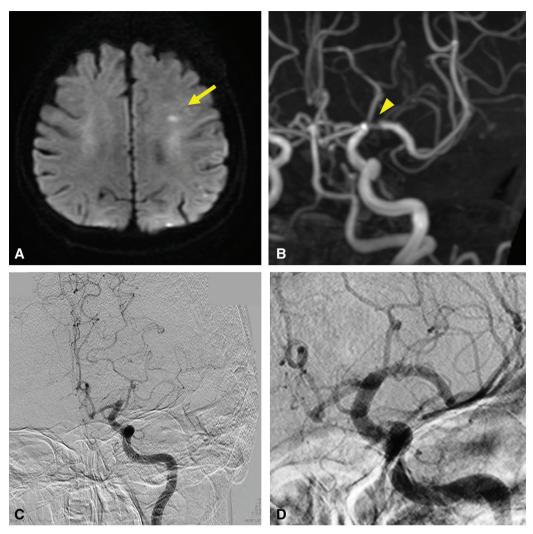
MRI revealed a new spot lesion (arrow) on the left frontal lobe (A) and MRA showed abnormal visualization (arrowhead) of the left M1 (B). Angiography revealed re-occlusion of the left M1 (C), and thrombectomy was performed again and successfully achieved recanalization. After 25 min of thrombectomy, there was no evidence of re-occlusion (D).
